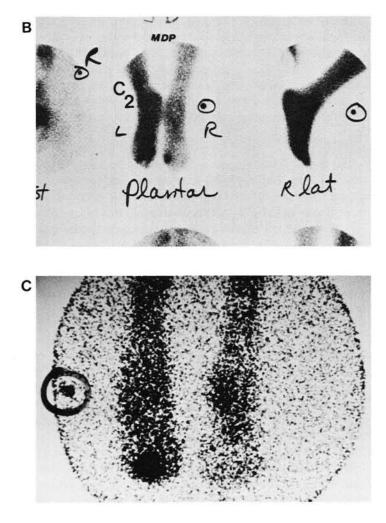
A. Radiograph of suspected osteomyelitis of second MTPJ in left foot of diabetic patient. B. Technitium-99 bone scan (delayed image) demonstrates marked activity in left foot and second MTPJ area. C. Indium-111 scan shows increased activity in second MTPJ area strongly suggesting osteomyelitis.
